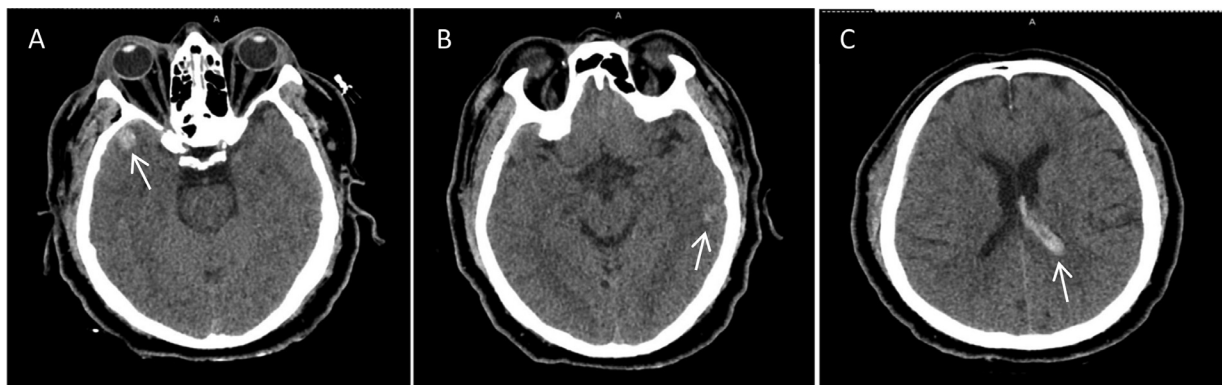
Initial non-contrast CT of the head showing anteroinferior right temporal lobe IPH (white arrow, A), petechial hemorrhage of left temporal lobe (white arrow, B), and intraventricular left ventricle hemorrhage (white arrow, C).
